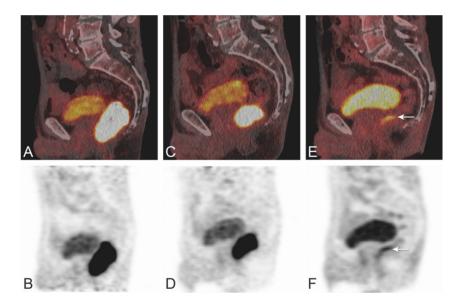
Response monitoring locally advanced rectal cancer. Images show PET/CT (A, C, E) and PET (B, D, F) images before (A, B), two weeks into treatment (C, D) and 6-8 weeks after neoadjuvant treatment (E, F).
